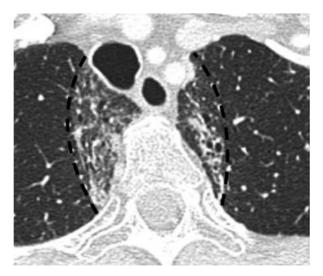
Classic radiation fibrosis pattern: contrast-enhanced axial CT image shows classic well-demarcated linear opacities (dashed lines) corresponding to radiation field in a patient who received conventional external beam radiation to treat head and neck cancer.
